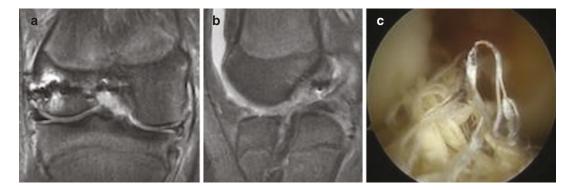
(a) Coronal MRI (b) Sagittal MRI (c) Arthroscopic imaging of ACL graft failure
